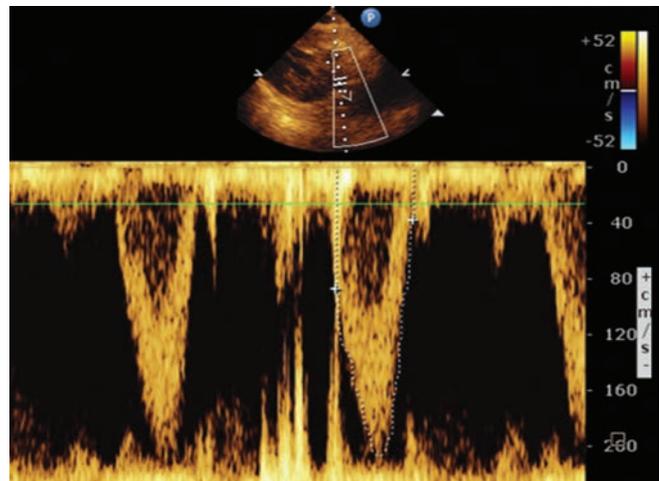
TEE Pulse wave Doppler. Shows LVOT gradients by pulsed Doppler obtained in the transgastric view.
